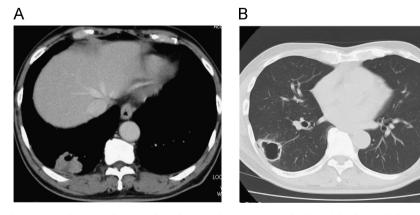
(A) Computed tomographic (CT) image showing a primary tumor in the right lower lobe with a cavitation diameter greater than 10 mm. (B) CT image showing a primary tumor in the right lower lobe with an irregular cavitation wall with a thickness >1 mm.
